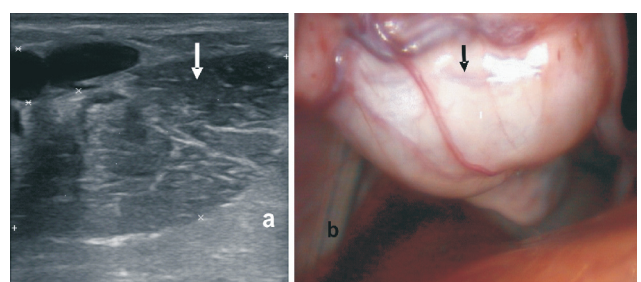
Tubo-ovarian abscess (arrow). (a) Ultrasound image (b) Laparoscopic image.
